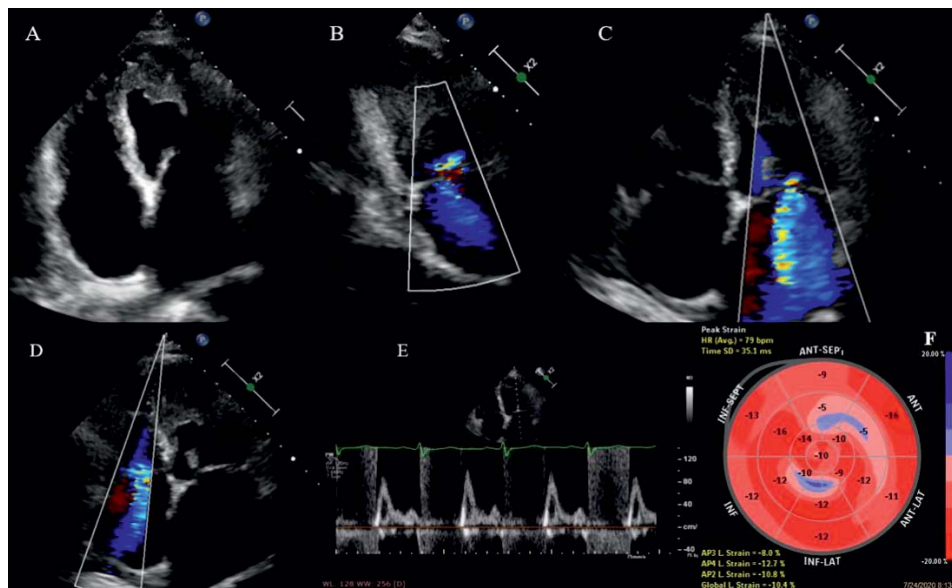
Transthoracic Echocardiography: A. Apical four-chamber view- Left ventricular apical obliteration with mural thrombus. B, C. Apical four chamber and two chamber view-mitral regurgitation. D. Apical four-chamber view-tricuspid valve regurgitation. E. Restrictive flow pattern across mitral valve. F. Left ventricular endomyocardial systolic dysfunction.
